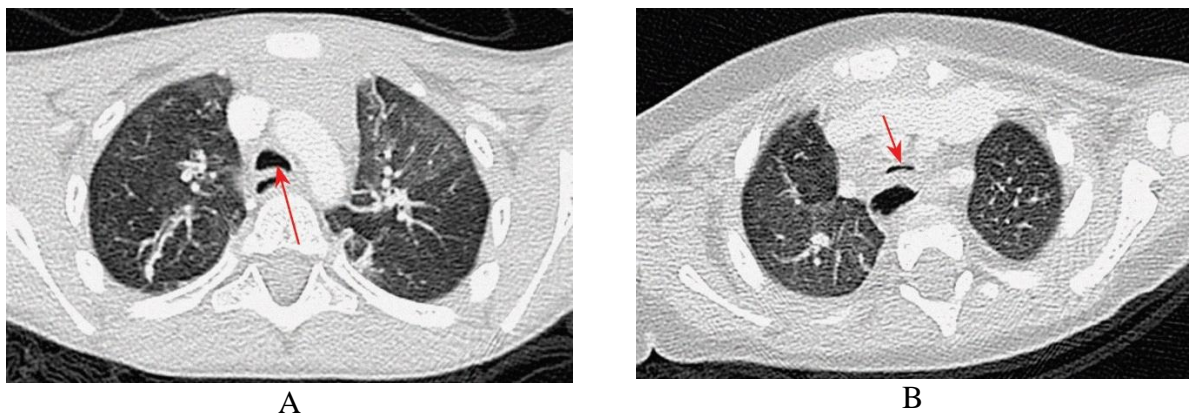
Computed tomography in patients with different variants of tracheomalacia. A – idiopathic tracheomalacia, patient’s age 2 years and 4 months. Obstruction of the trachea caused by inward prolapse of the widened membranous wall (arrow). B – tracheomalacia associated with esophageal atresia, patient’s age 4 months. Slit-like shape of tracheal lumen. Tracheal obstruction is caused by closing of the anterior and posterior walls due to loss of cartilage rigidity and widening of the membranous wall
